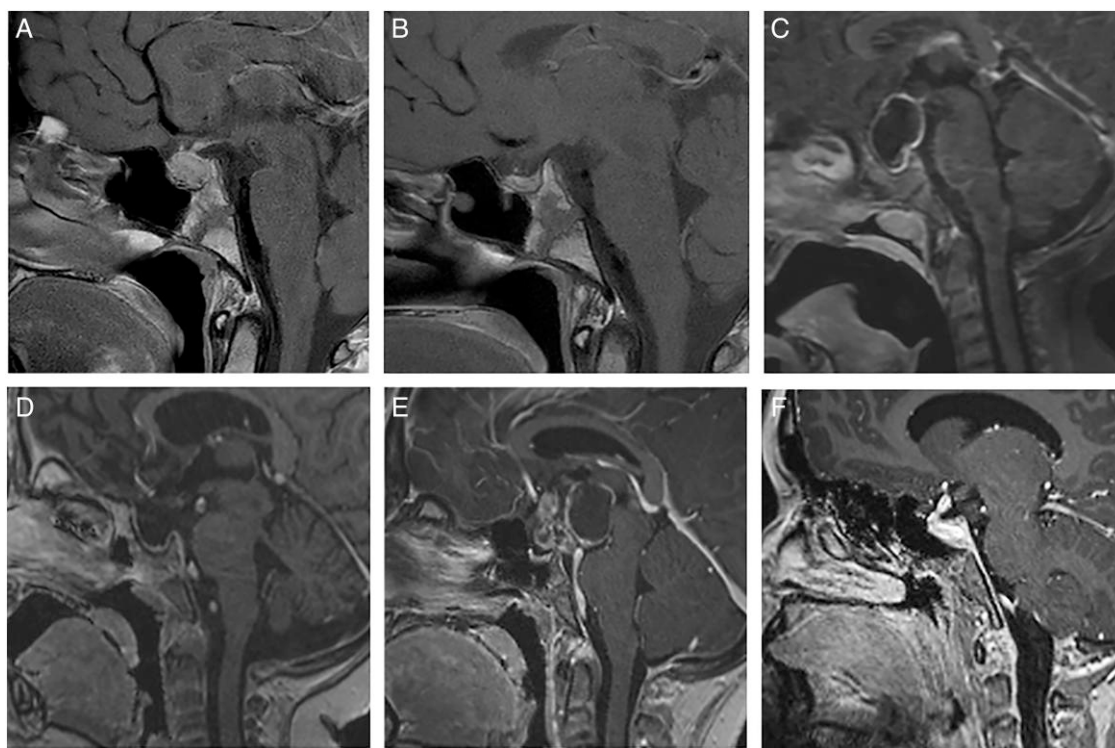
Radiological assessment of hypothalamic damage. Pre- and post-operative MRI images with classification of craniopharyngioma according to the degree of hypothalamic involvement/surgical lesions using the Muller score.¹⁵ (A/B) Grade 0 (0°), no hypothalamic involvement/lesion. (C/D) Grade 1 (I°), hypothalamic involvement/lesion of the anterior hypothalamus not involving the mammillary bodies and the hypothalamic area beyond mammillary bodies. (E/F) Grade 2 (II°), hypothalamic involvement/lesion of the anterior and posterior hypothalamic area, ie, involving the mammillary bodies and the area beyond mammillary bodies.
